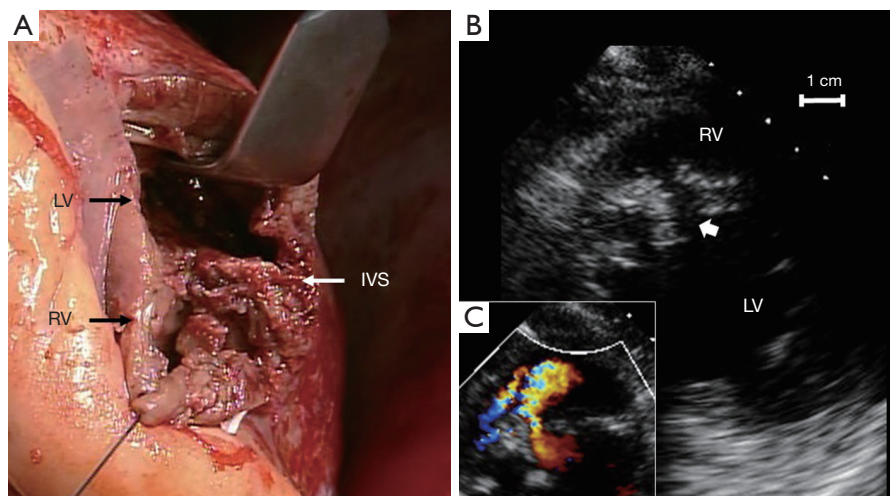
Intraoperative imaging and echocardiography after surgery. (A) During surgery, a large defect within the necrotic interventricular septum (IVS) was observed; (B) transthoracic echocardiography in the parasternal short axis view after surgery; (C) color flow imaging showed small shunt flow. LV, left ventricle; RV, right ventricle.
